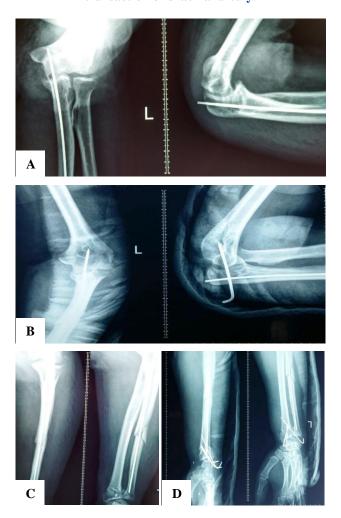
(A-D): Post-operative radiographs.
